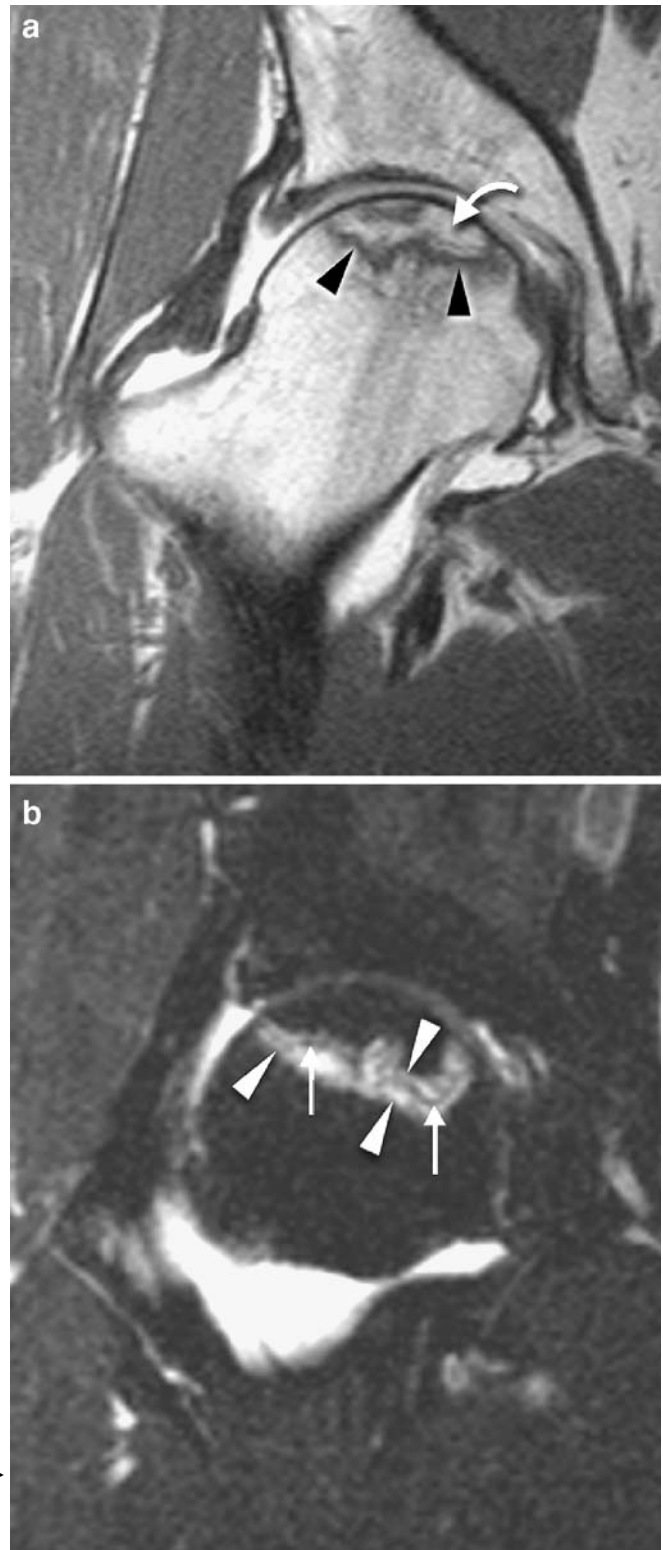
MR arthrography findings in avascular necrosis of the femoral head. a On the T1-weighted spin echo image a serpiginous line of low signal (*arrowheads*) surrounding an area of fatty marrow (*curved arrow*) is seen anterosuperiorly. b On the fat-suppressed T2-weighted turbo spin echo image a hypodense serpiginous line (*arrows*) is paralleled by an inner and outer hyperintense line (*arrowheads*). These lines represent granulation tissue at the interface of necrotic and viable bone
